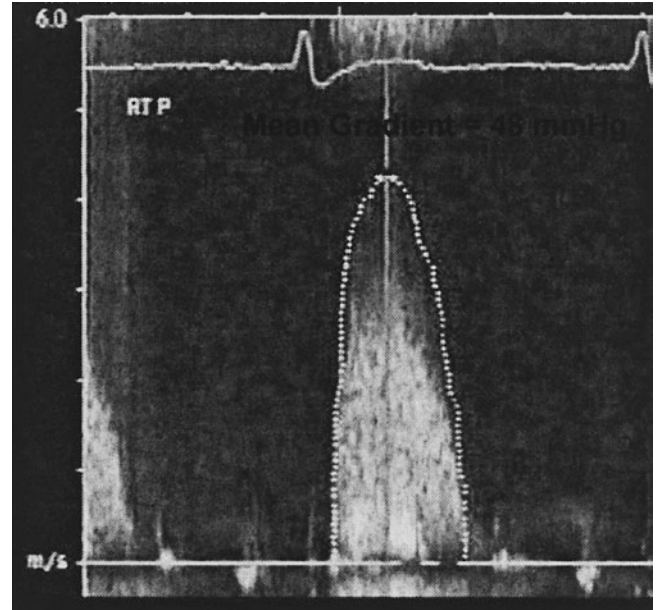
Continuous-wave Doppler obtained from the right parasternal window (RT P) in a patient with severe aortic stenosis (AS). The peak velocity is more than 4 m/s, and the mean gradient is 48 mm Hg.
